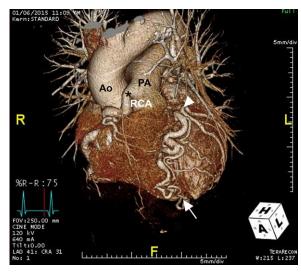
Cardiac computed tomographic angiogram shows the origin of the right coronary artery (asterisk, RCA) from the pulmonary artery (PA), the origin of the left anterior descending coronary artery from the aorta (arrowhead), and dilated epicardial coronary arteries and prominent left-to-right collateral vessels (arrow). A congenital condition, ARCAPA constitutes 0.12% of all coronary anomalies.¹ About 50 cases of ARCAPA have been reported; most were diagnosed in infants and children.² In comparison with anomalous left coronary artery arising from the PA, ARCAPA is slightly rarer (incidence, 0.002% vs 0.008%), usually presents later in life, and is less likely to present with congestive heart failure, myocardial ischemia, or sudden cardiac death.³ In individuals with ARCAPA, a coronary artery steal phenomenon can develop between the pulmonary and systemic arterial beds resulting from reverse coronary flow in the anomalous artery.¹ After birth, pulmonary vascular resistance decreases, and the degree of early collateralization will predict the natural course in these patients. As imaging methods continually become more
